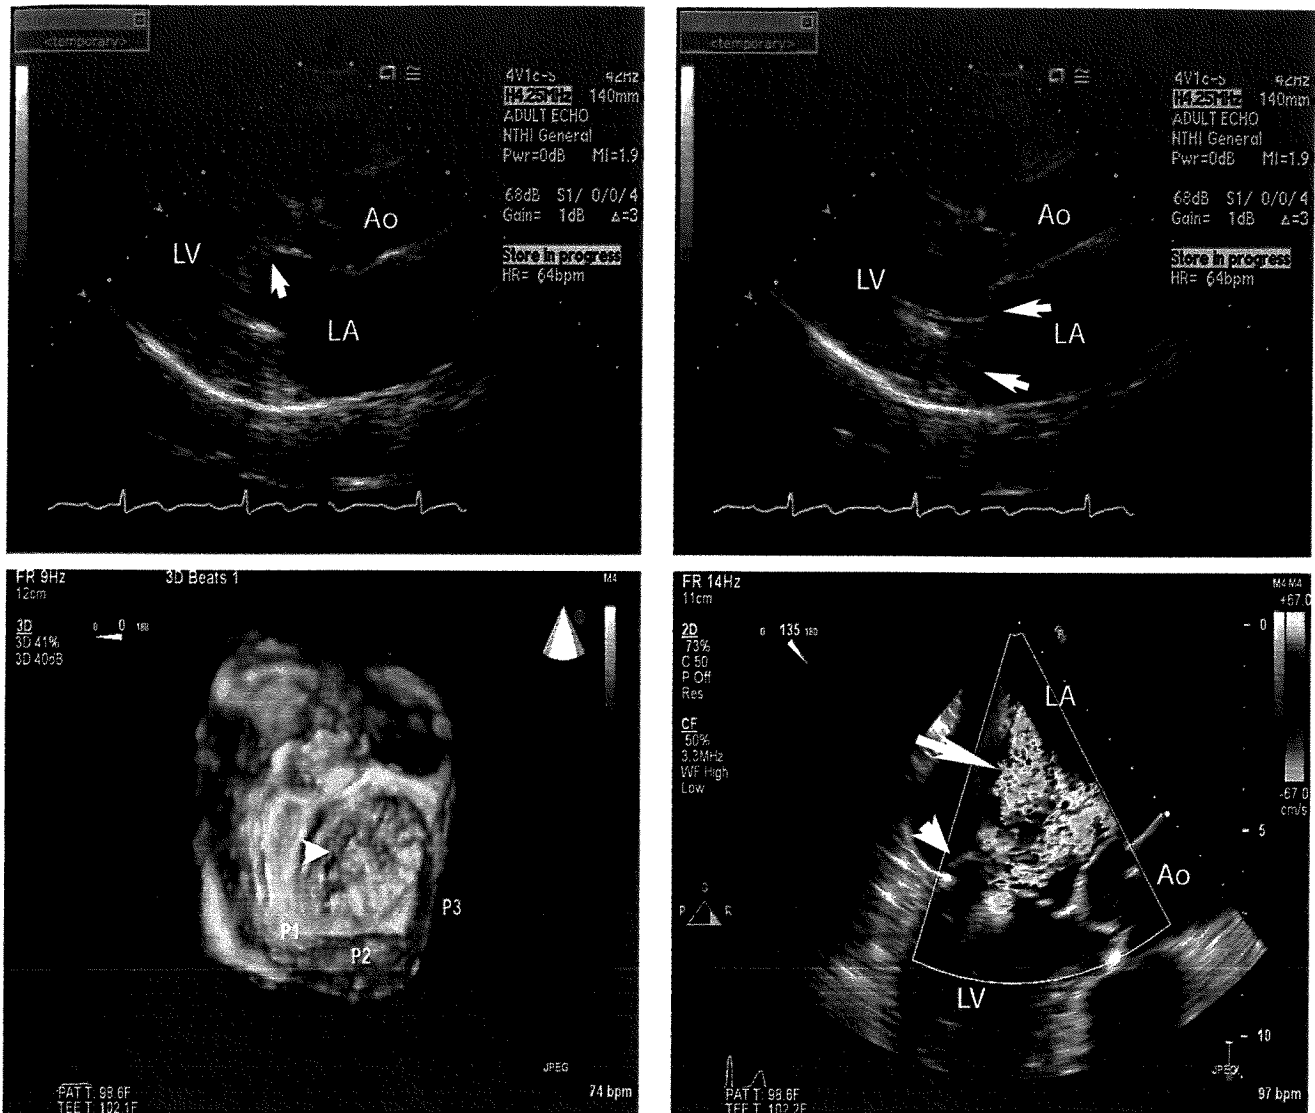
Mitral valve prolapse. Echocardiogram showing normal opening of the mitral valve (arrow, top left panel), which then prolapses into the left atrium during systole (arrows, top right panel). In a different patient with myxomatous degeneration, a flail portion of the posterior mitral valve is present (bottom panels); torn chordae are seen (arrowheads), leading to severe regurgitation seen on color flow imaging (arrow, bottom right panel). Ao = ascending aorta; LA = left atrium; LV = left ventricle.
